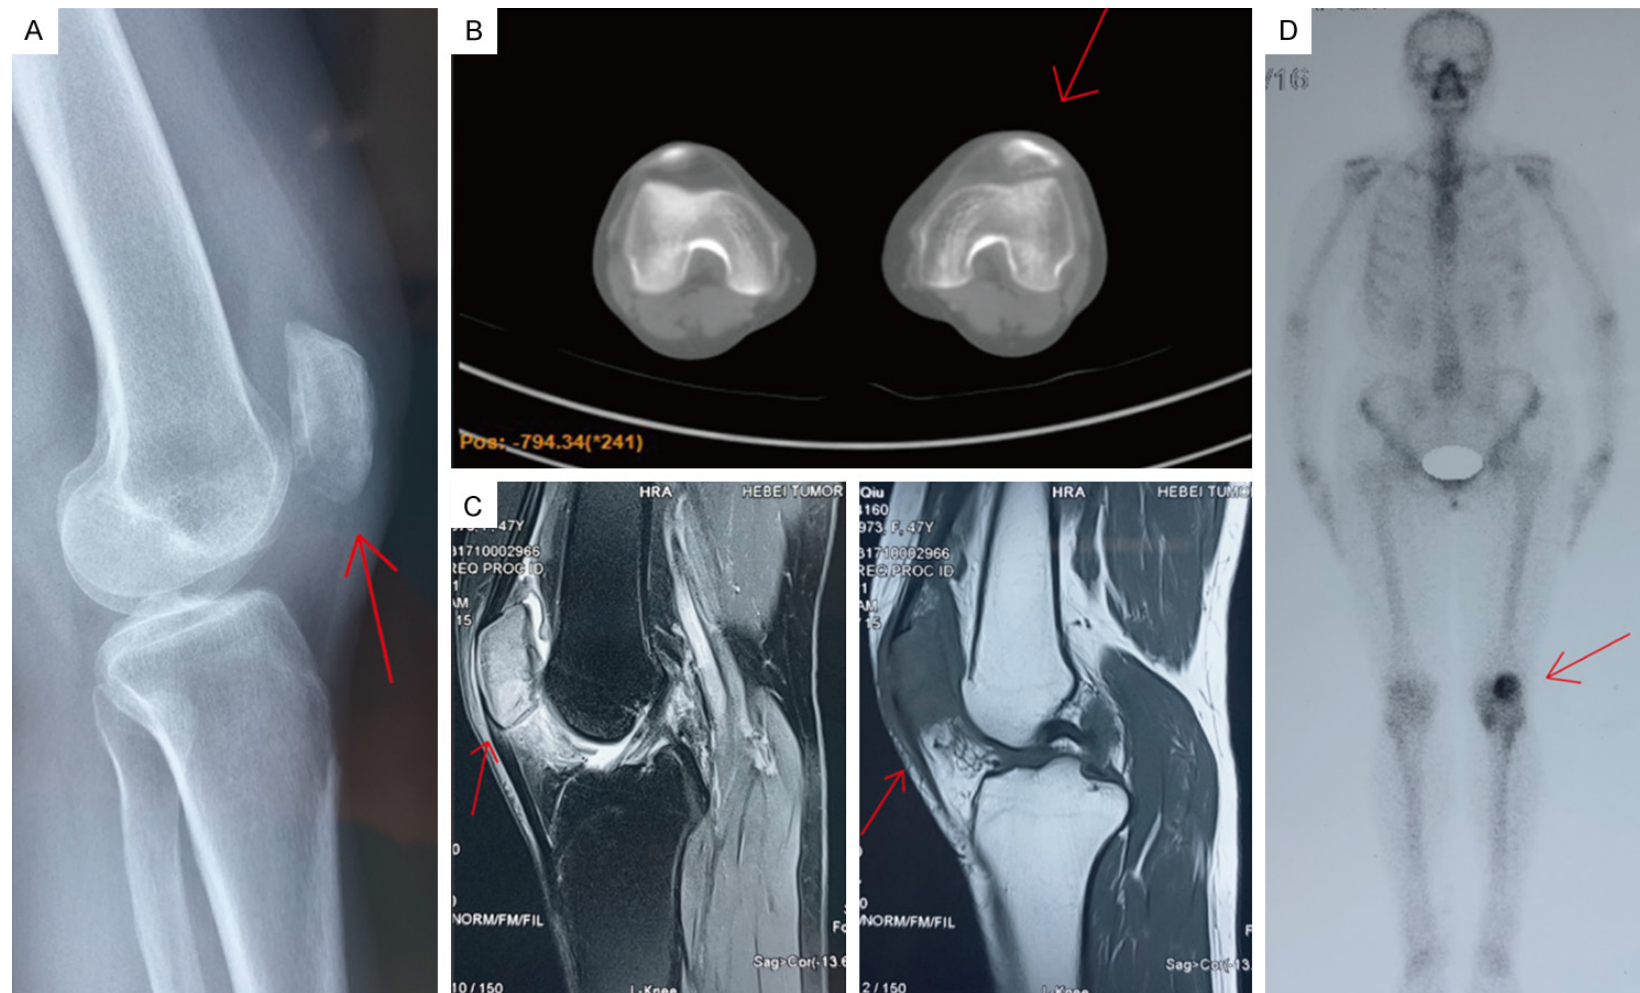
The patient's preoperative series of auxiliary examination data. A. Radiography indicated a reduced bone density of the left patella; B. CT scan indicated osseous destruction of the left patella; C. MRI examination indicated abnormal signal in the left patella; D. ECT scan indicated an unusual concentration of signal in the left patella.
